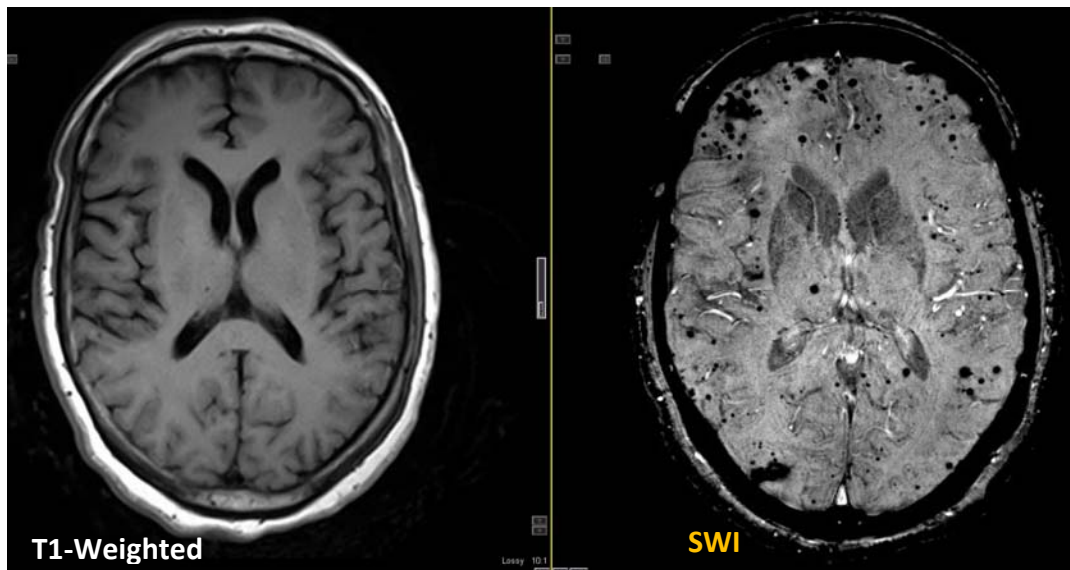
Comparison of T1-weighted and SWI images for cerebral amyloid angiopathy, another disorder involving multiple small brain hemorrhages in the elderly.
